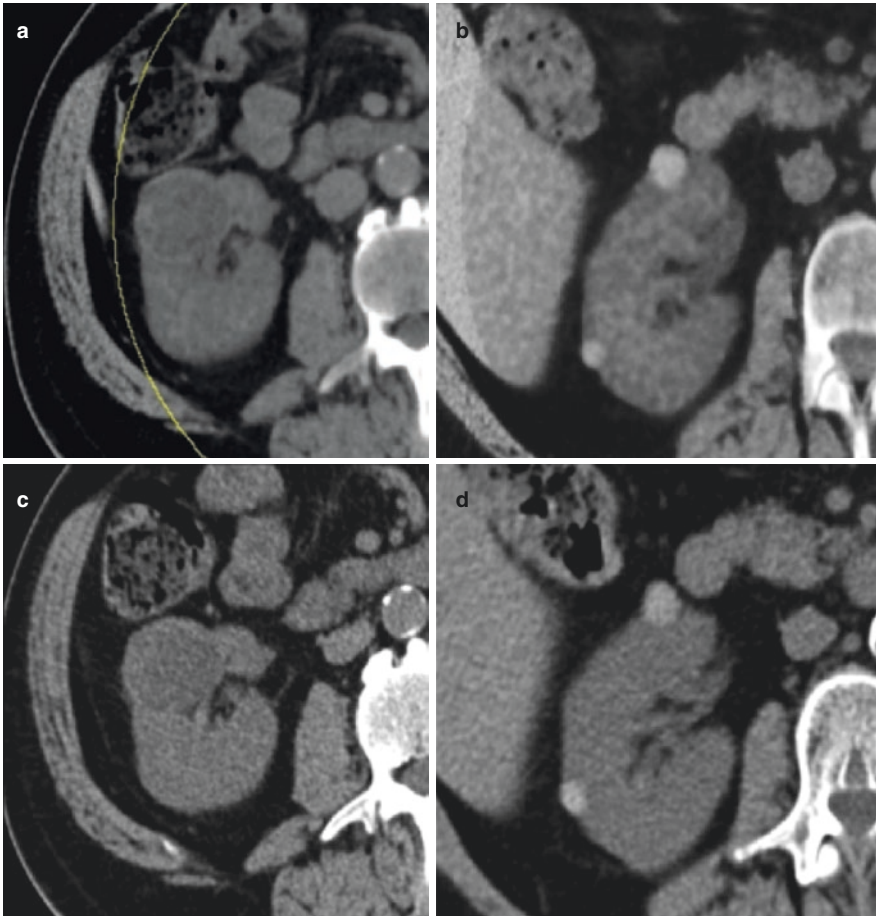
Post-processed virtual non-contrast axial CT images of a simple renal cyst (a) and of an hemorrhagic renal cyst (b) show almost the same density as compared
